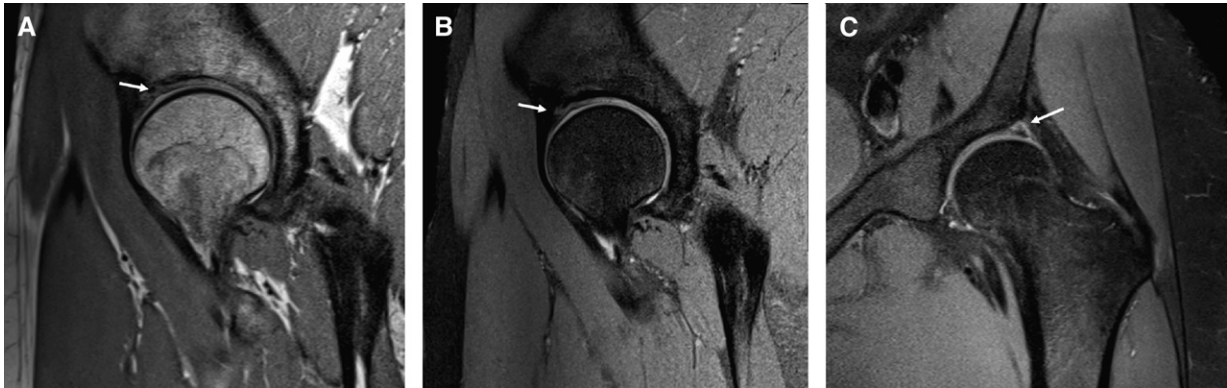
Labral tear. (A) Sagittal turbo spin-echo (TSE) proton density (PD)-weighted 3T magnetic resonance imaging (MRI) and (B, C) sagittal and coronal fat-saturation TSE PD-weighted 3T MRI of the left hip, showing a small anterosuperior labral tear (white arrows).
